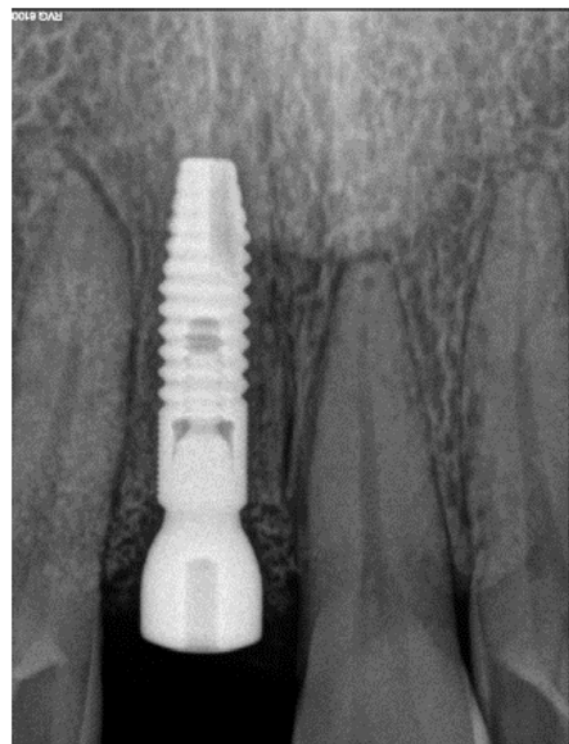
Post-surgical periapical radiograph.
